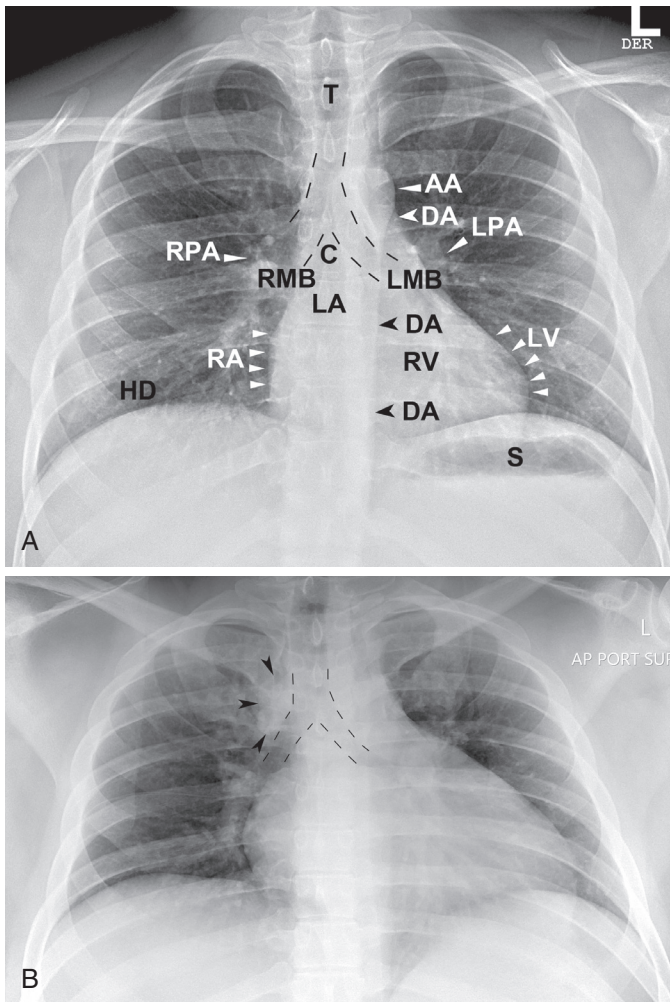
■ A, Posteroanterior (PA) upright chest x-ray. B, Anteroposterior (AP) supine view of the same patient. Note magnification of heart and mediastinum. Shallow inspiration increases vascular resistance making the perihilar and interstitial markings (pulmonary vessels) more prominent, as well as the azygos vein (*outlined by arrowheads*). AA, aortic arch; C, carina; DA, descending aorta; HD, hemidiaphragm; LA, left atrium; LMB, left main stem bronchus; LV, left ventricular border; RA, right atrial border; RMB, right main stem bronchus; RV, right ventricular body; S, stomach; T, trachea.
